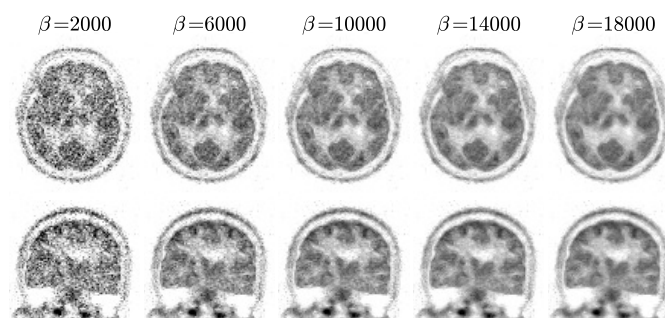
Real data FDG-guided MAPEM reconstructions as a function of  $\beta$ , using the same weights parameters as were used in figure 10. Noise levels decrease as  $\beta$  increases, without visually affecting the pattern of distribution of the radiotracer.
